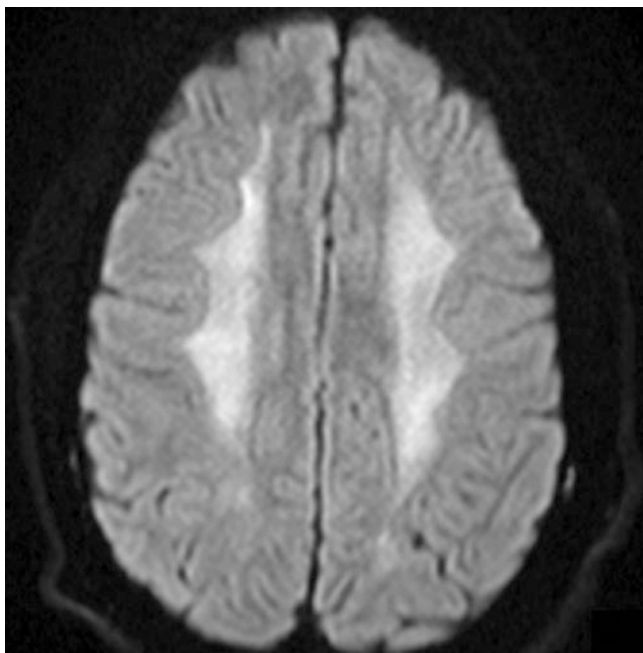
Delayed post-hypoxic leukoencephalopathy. Patient with respiratory failure due to heroin overdose presents with progressive mental status decline. The axial DWI image shows confluent diffusion restriction in the bilateral cerebral white matter
